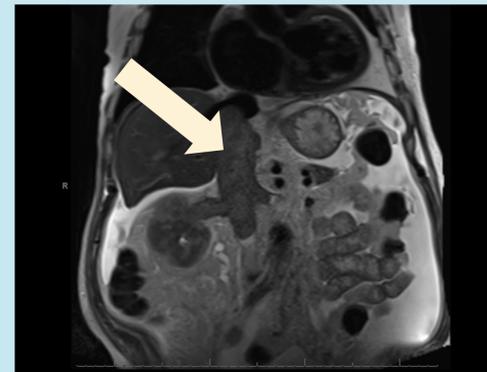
MRI of the abdomen further revealed a thrombus (arrow) within the right renal vein and IVC that extended below the right atrium.
